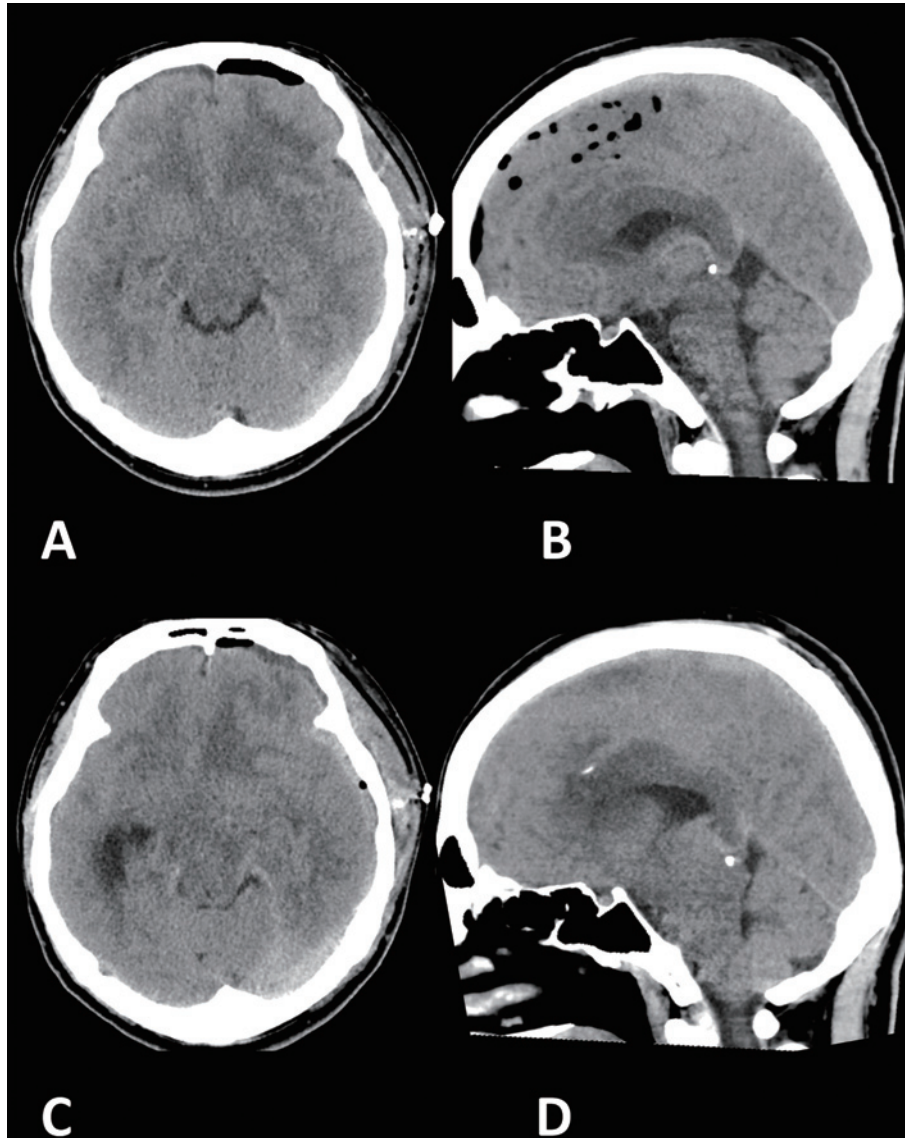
(AB) Brain CT performed on POD 1, which had been considered unremarkable. A, axial image; B, sagittal image. (CD) Brain CT performed on POD 4 showing the presence of a subdural hematoma, brain shift > 10 mm, and effacement of the preponine cistern. C, axial image; D, sagittal image.
